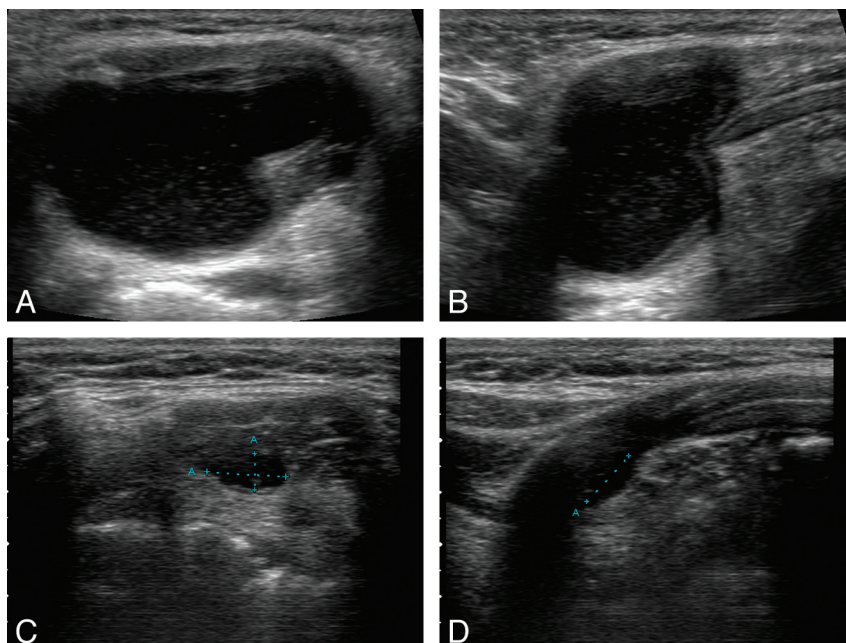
A 41-year-old woman (patient 10). Axial (A) and longitudinal (B) sonograms show the TGDC in a suprahyoid location ($2.0 \times 2.3 \times 3.1$ cm; volume, 7.46 mL) filled with fluid. Axial (C) and longitudinal (D) sonograms obtained 13 months after EA show marked shrinkage of the TGDC. ($0.35 \times 0.6 \times 0.76$ cm; volume, 1.08 mL; volume reduction, 85.5%)
